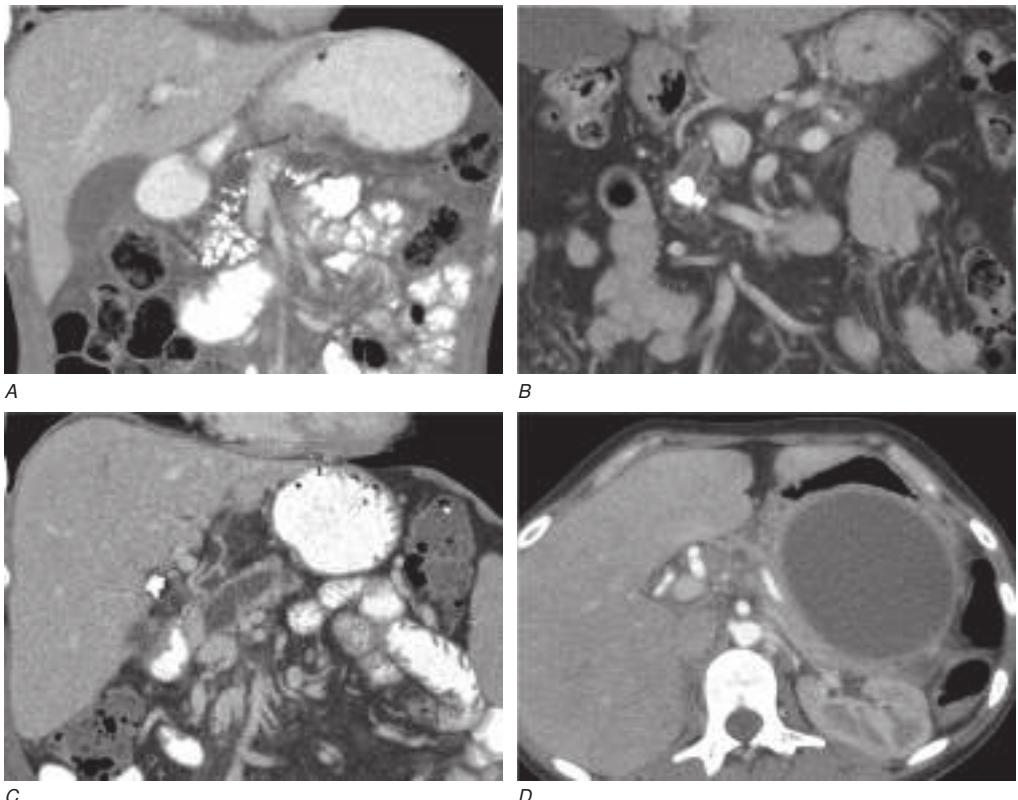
Distribution of imaging features of chronic pancreatitis on computed tomography (CT). Distinct features of chronic pancreatitis are seen on selected images from contrast-enhanced CT scans of the abdomen from four unique patients, including the following. *A*. Numerous punctate calcifications involving the pancreatic parenchyma in the head and body. *B*. A moderate-sized calculus visualized in the pancreatic duct with associated ductal dilation. *C*. Significant pancreatic duct dilation and adjacent parenchymal atrophy secondary to a pancreatic duct stricture (which is not well seen on this scan). *D*. A large unilocular, encapsulated cyst in the tail of the pancreas consistent with a pseudocyst from prior pancreatitis. Note adjacent pancreatic parenchymal atrophy.
